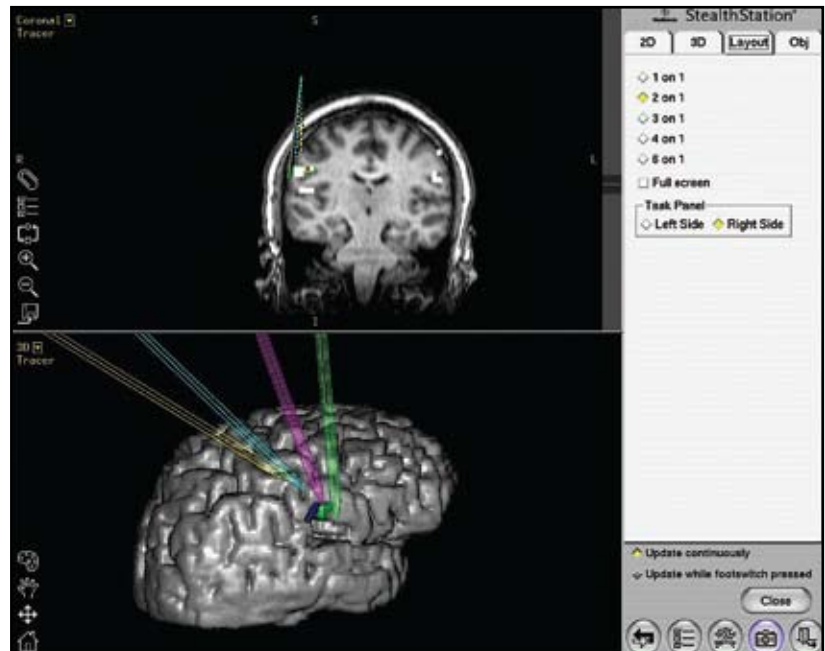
Motor cortex stimulation to treat centrally mediated facial pain. Magnetic resonance imaging (MRI) delineates the location of an electrode with 4 contacts placed across the target—the face area of the motor strip, as defined by a functional MRI scan.
